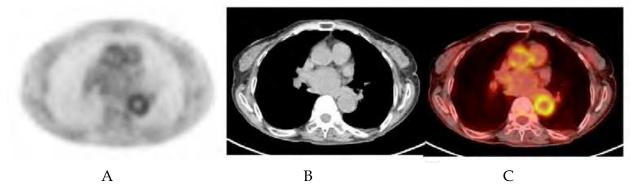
Axial view showing hyper metabolism of the ascending and descending wall of thoracic aorta, indicating aortitis (A: PET, B: CT scan, C: images fused PET-CT).
